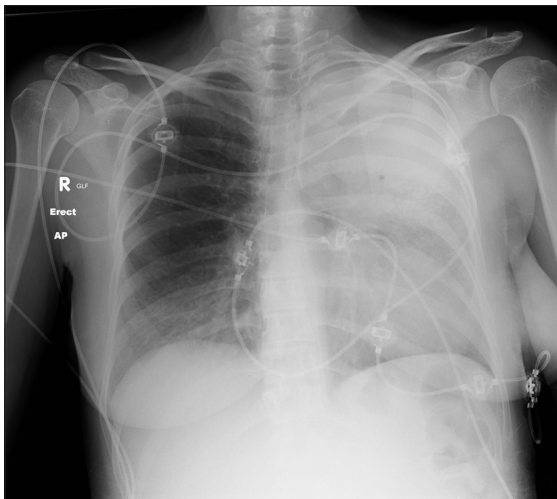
Chest X-ray on presentation to emergency department
